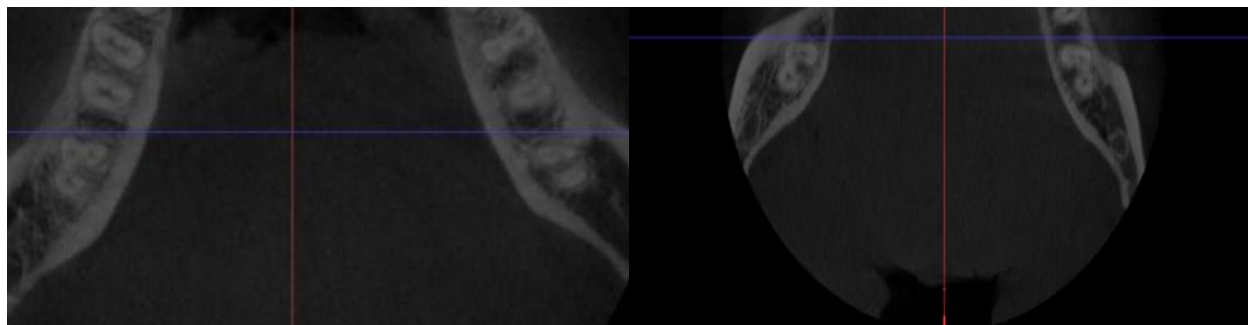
CBCT image of the mandibular second molar C3-shaped canal.
